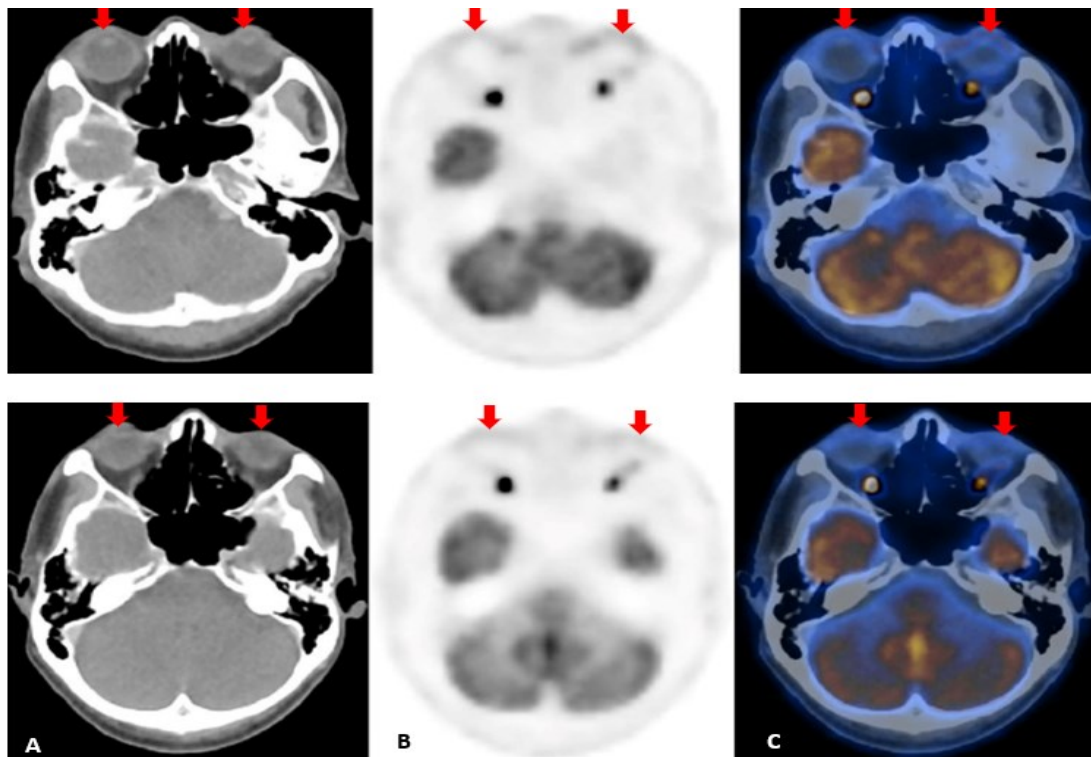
Axial view of the orbit showing the (A) CT, (B) PET, and (C) fused PET/CT images of the follow-up whole-body PET/CT scan with emphasis on the preseptal regions (red arrows). First PET/CT scan (1st row) and follow-up PET/CT scan (2nd row).
